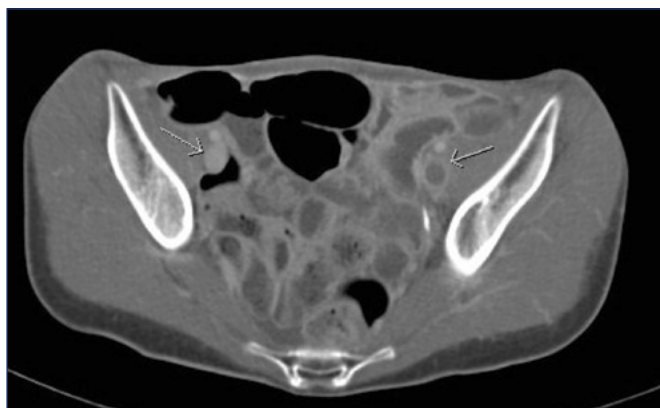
Indirect computed tomographic (CT) venography. Acute left iliofemoral deep-vein thrombosis; note the difference in attenuation between the two sets of external iliac veins.
